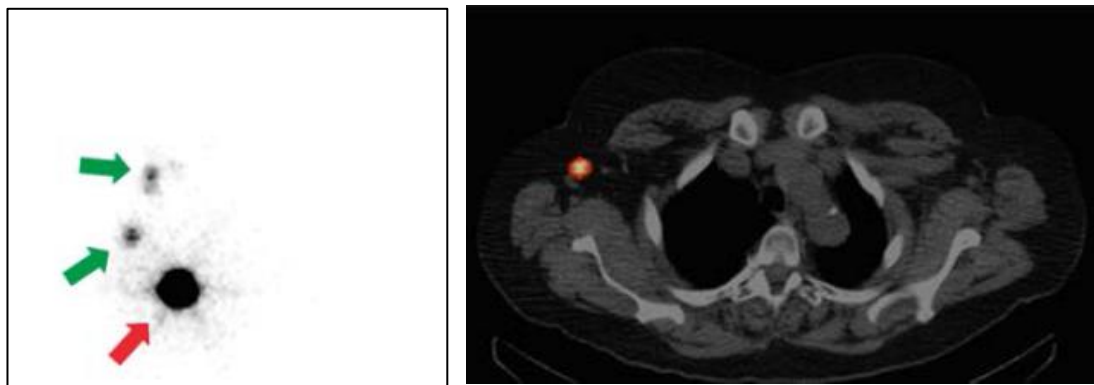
Example of lymphoscintigraphy (left) and axial plane of SPECT-CT imaging (right) performed using clinical camera systems prior SLNB procedure, taken from [143]. Red arrow indicates the injection site and the green arrows show the sentinel nodes.
